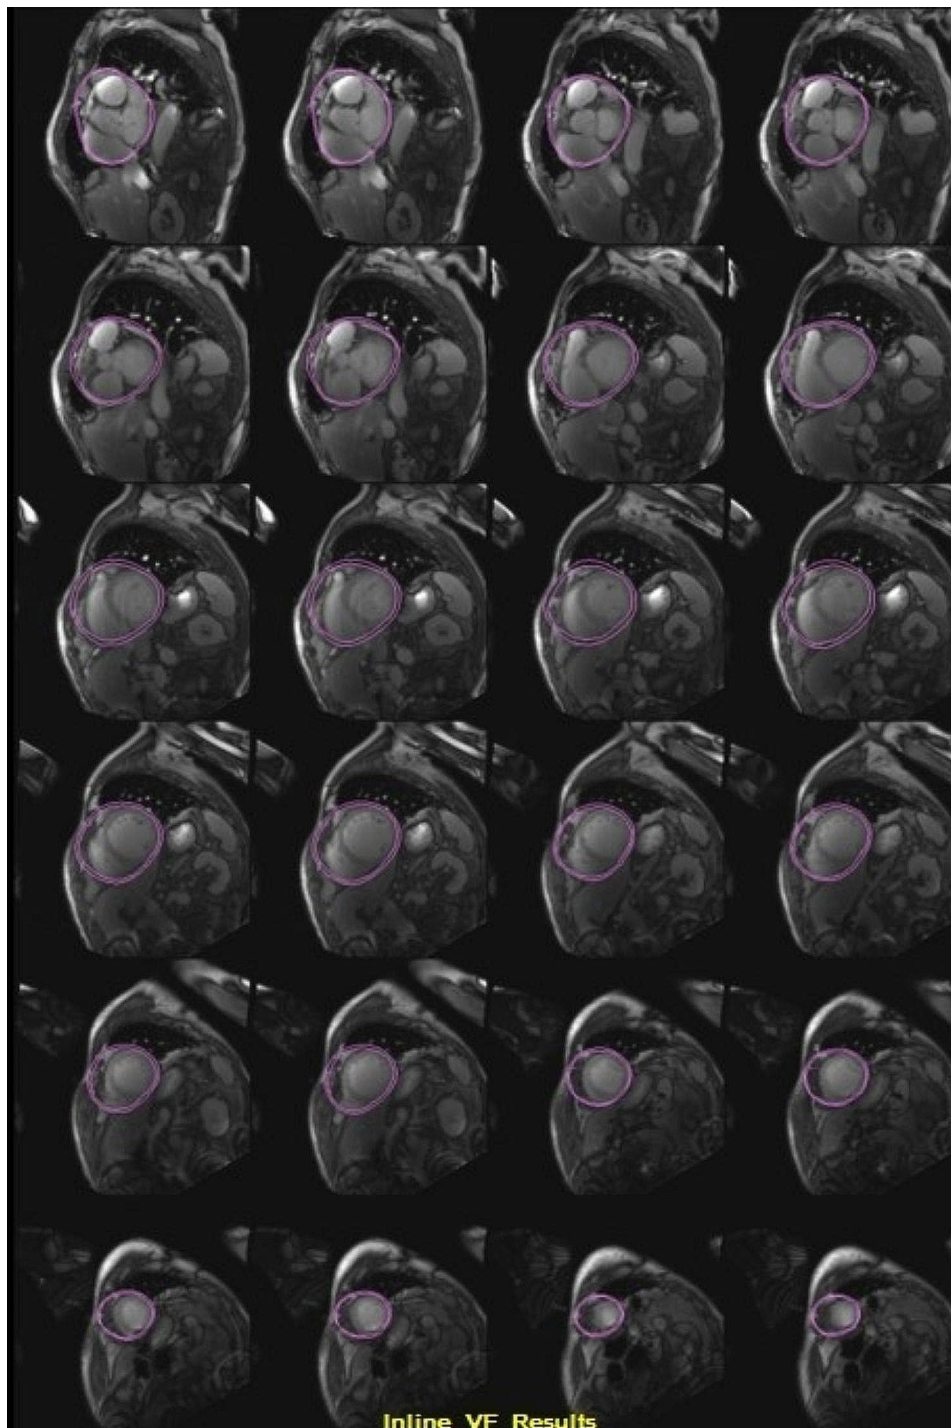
The patient's cardiac magnetic resonance images
